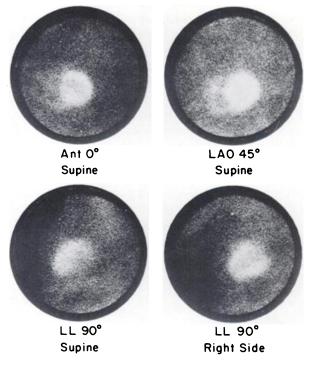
Thallium-201 scintigraphy in four projections in Case 1, with normal coronary arteries. Images were obtained 10 min following injection. Inferoposterior defect is seen on LL image in supine position, but is not apparent on LL image with patient on his right side. Anterior and 45° left anterior oblique images (top) are normal.
